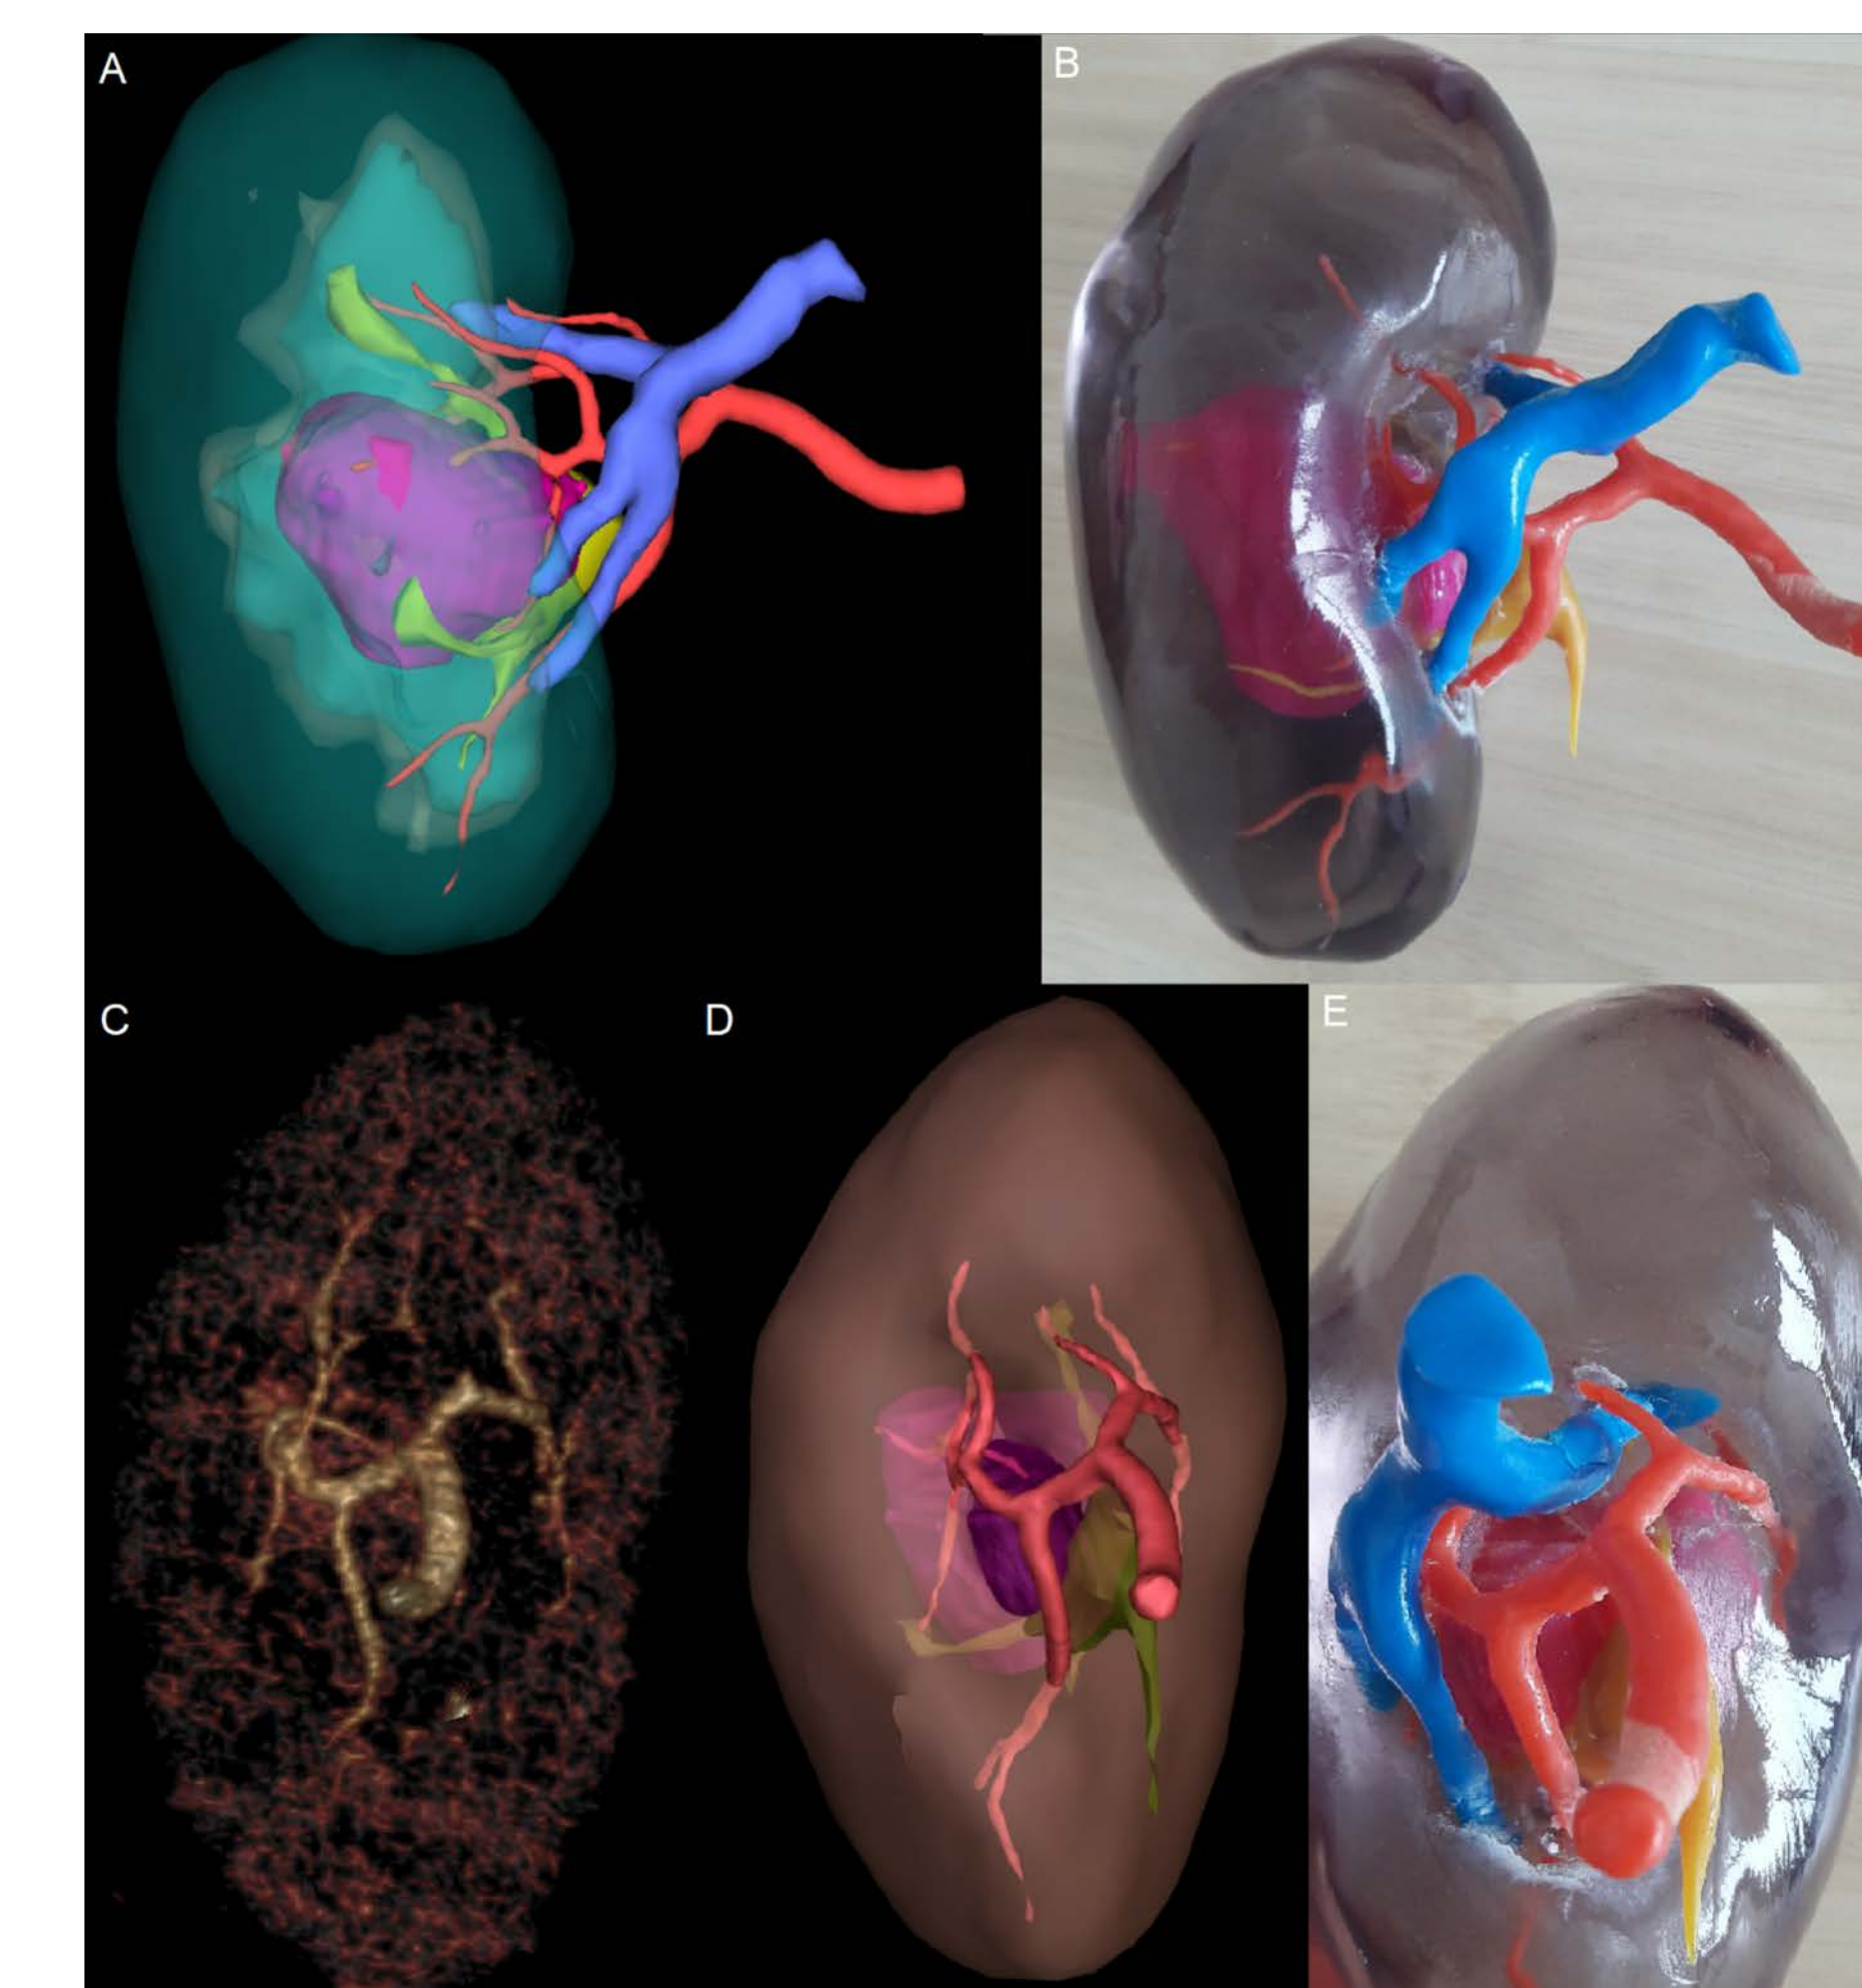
a.3D model ; b.3D printed model ; c. Volume rendering of CT-angiogram ; d.3D model same viewpoint ; e. 3D printed model same viewpoint
